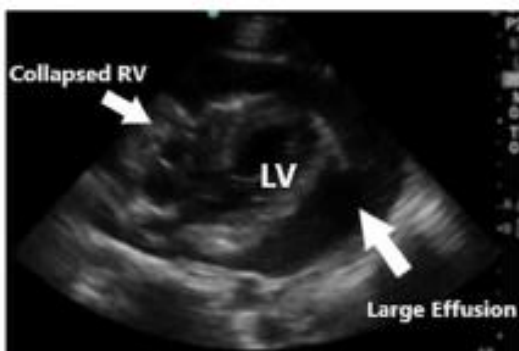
An echocardiographic image taken in the parasternal long-axis view demonstrates a large effusion causing right ventricular collapse during diastole.
